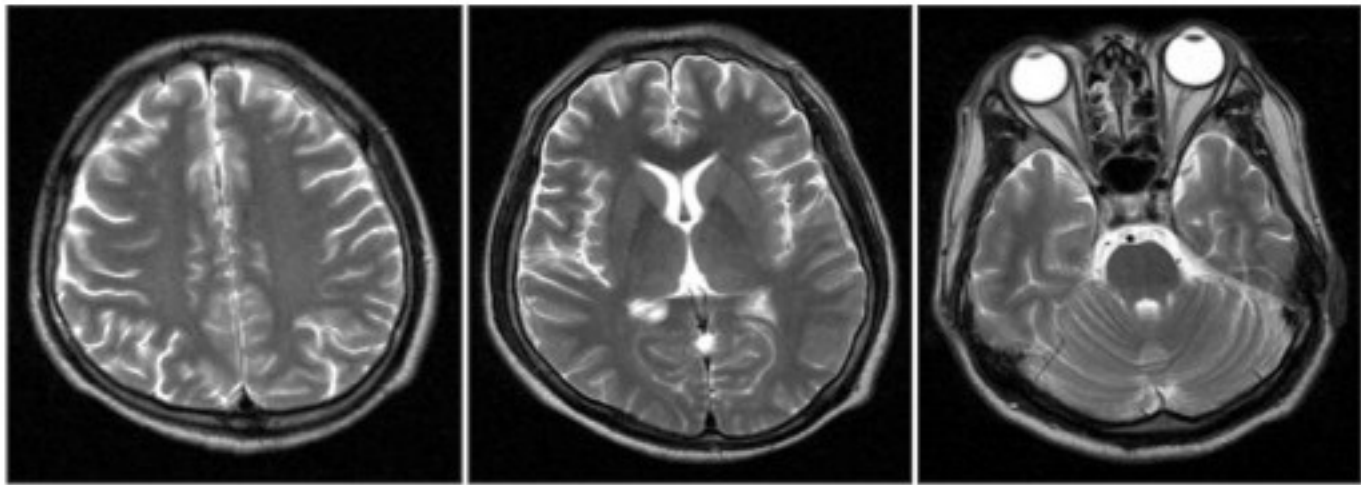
The T2-weighted images of brain magnetic resonance imaging show mild diffuse brain atrophy.
